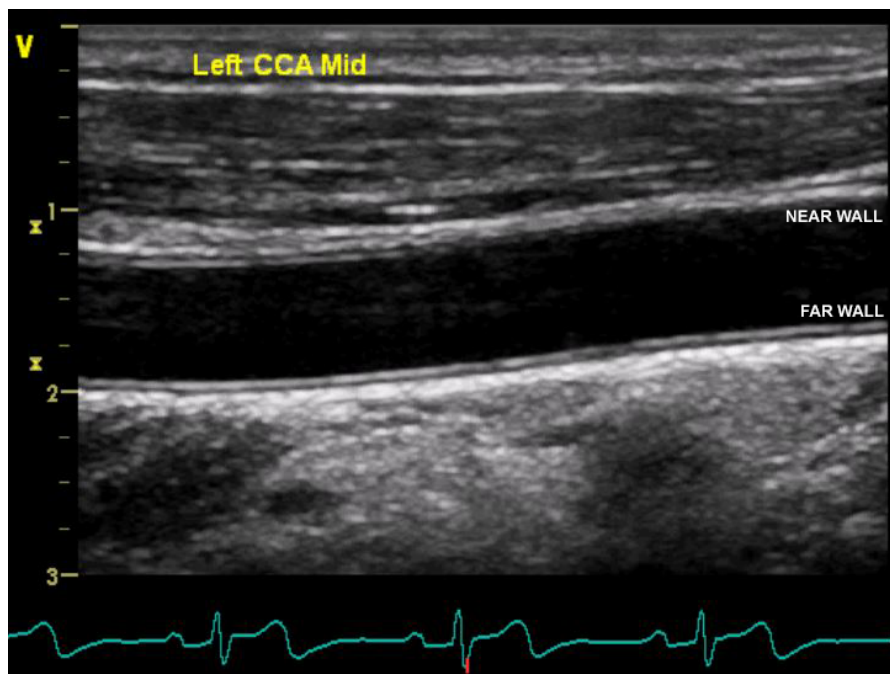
B-mode image from a healthy human left common carotid artery (CCA) using a contemporary ultrasound system. Note the typical ‘double tramline’ appearance of the intima-media complex with the echo-bright adventitia external to this.
